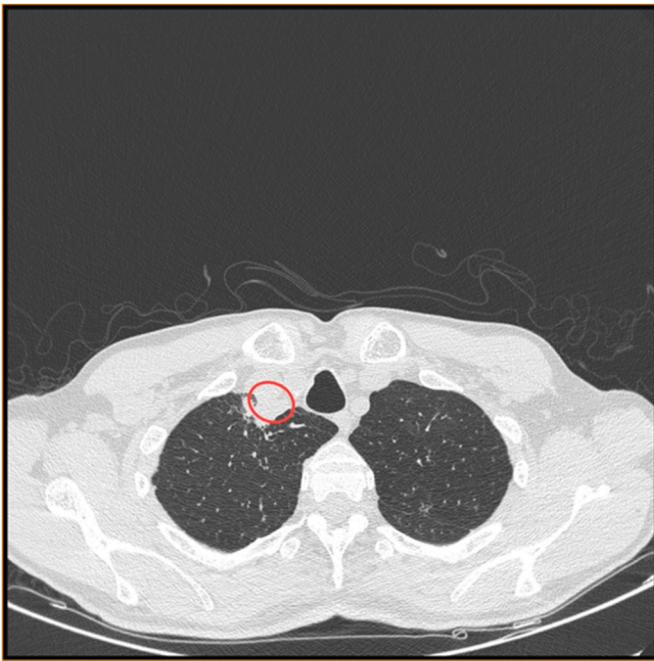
1. CT scan demonstrated the presence of a right paratracheal abscess.
